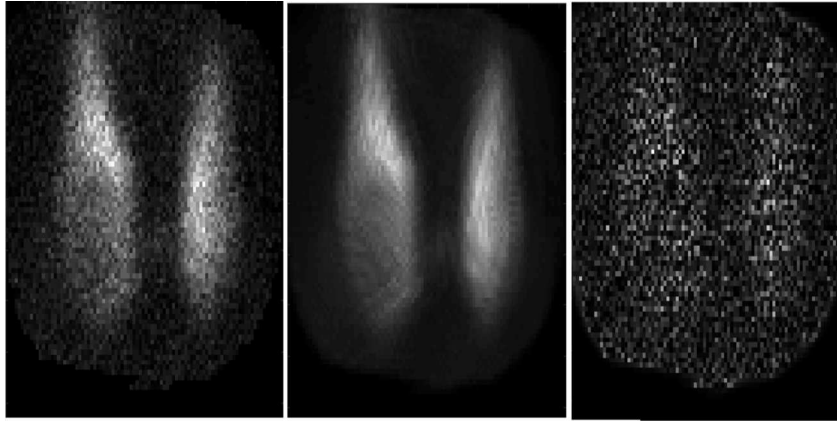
Demonstration of a) scintigraphic image of thyroid nodule, b) denoised scintigraphic image by OBNLM method with smoothing parameter ( $h=5$ ) and search area size ( $W=7$ ) and, c) corresponding residual image
